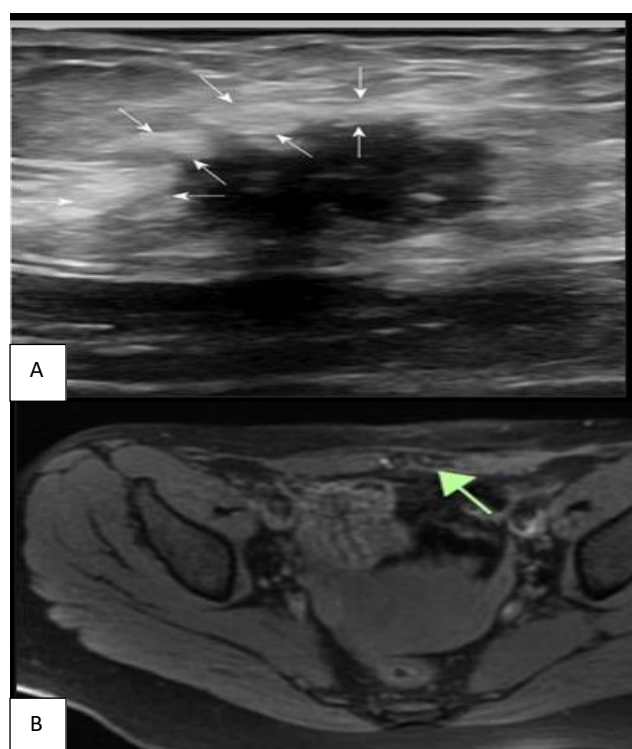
(A and B): ILI defined hypoechoic or hetero-echoic lesions were found in the USG. On MRI, there will be hyperintense heterogenous signal intensities on t1 and t2 images indicative of haemorrhage in glands.
